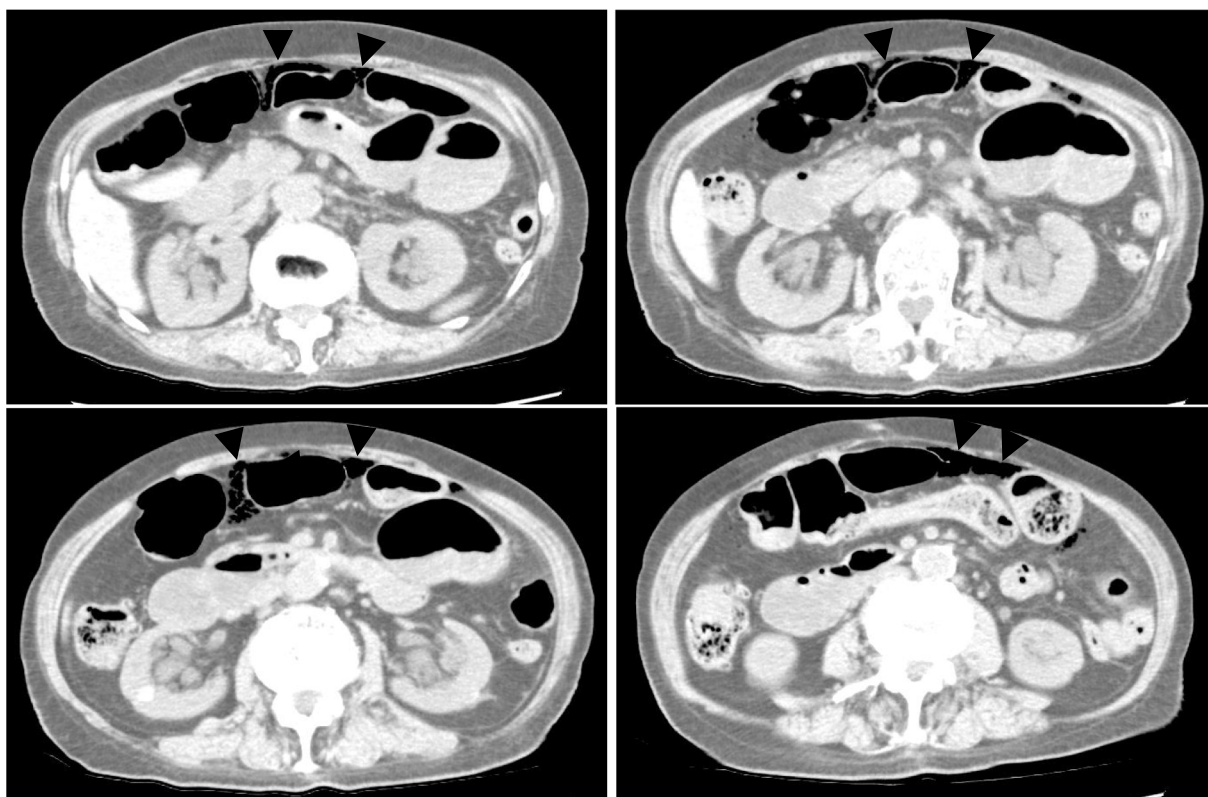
Contrast-enhanced computed tomography of upper abdomen on the first day of admission. Arrowheads indicate a small amount of intra-abdominal free air above the duodenal and transverse colon.
